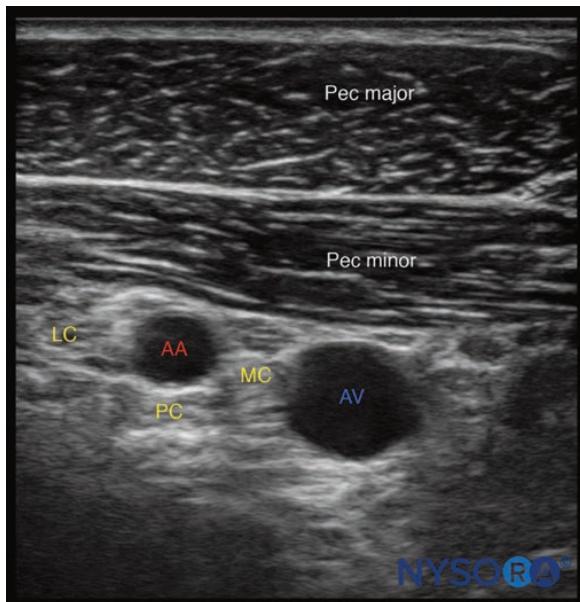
Infraclavicular block, ultrasound image. AA, axillary artery; AV, axillary vein; MC, medial cord; LC, lateral cord; PC, posterior cord.
